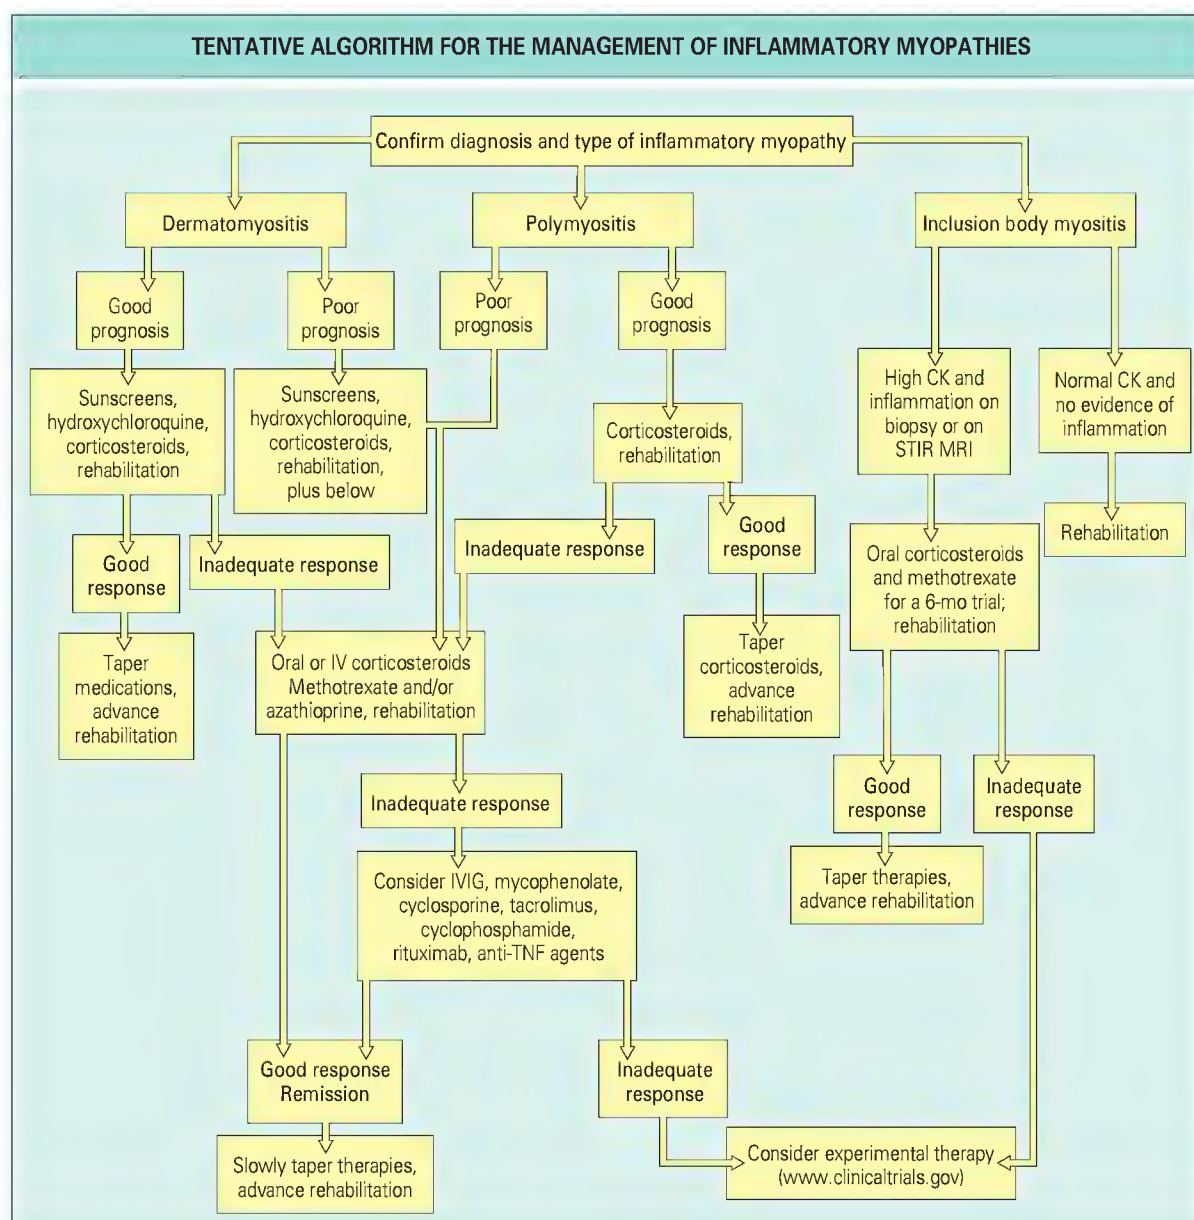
CK, creatine kinase; IV, intravenous; IVIG, intravenous immunoglobulin; MRI, magnetic resonance imaging; STIR, short tau inversion recovery; TNF, tumor necrosis factor.
